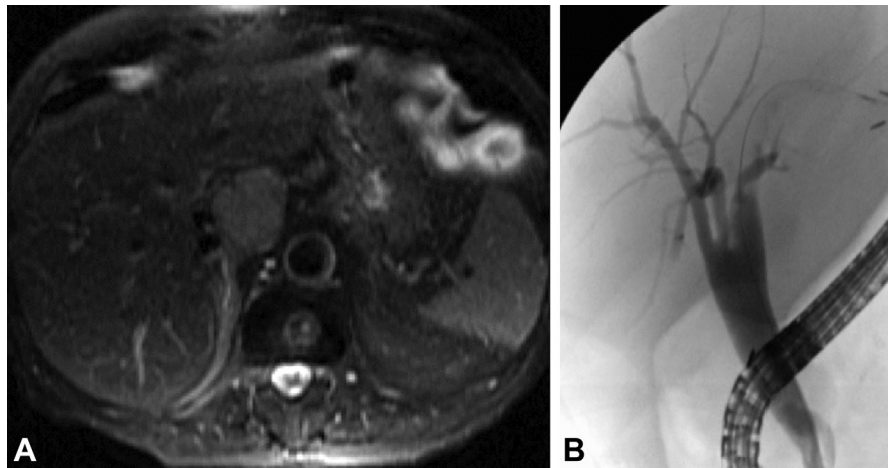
A, MRI view before RFA showing $4.4 \times 4.2 \times 5.9$ cm hyperintense mass with central enhancement and pronounced peripheral rim in the caudate lobe and mass in left hepatic duct. B, Cholangiographic view before RFA showing left hepatic ductal stenosis. *RFA*, radiofrequency ablation.
